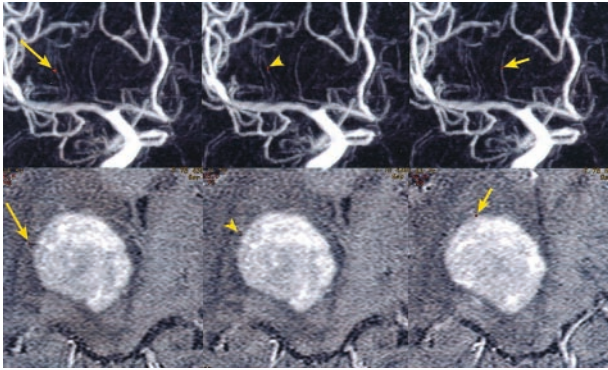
Common cursor image in a patient with a right thalamic malignant lymphoma. The image, which simultaneously displays 3D DSA (MIP) and axial contrast-enhanced MR images, clearly shows the relation between the tumor and two LSAs (*long arrow and arrowhead*) or one RAH (*short arrow*). The corresponding points are indicated as *small red dots*.
